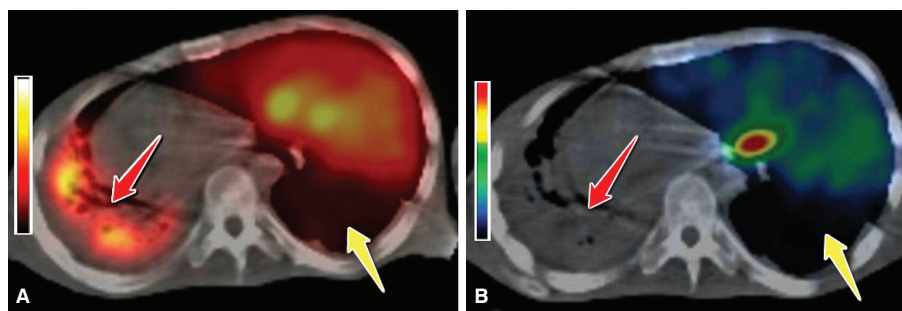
Perfusion (99mTc-MAA) and ventilation (Technegas) SPECT-CT transaxial scans. Perfusion (A) and ventilation (B) SPECT-CT transaxial scans show a collapsed right lung with severely reduced perfusion (A, red arrow) and lack of ventilation (B, red arrow). Matching defect of perfusion and ventilation is present in the lower left lobe (A, B, yellow arrows). The upper left lobe shows a normal perfusion and ventilation pattern
